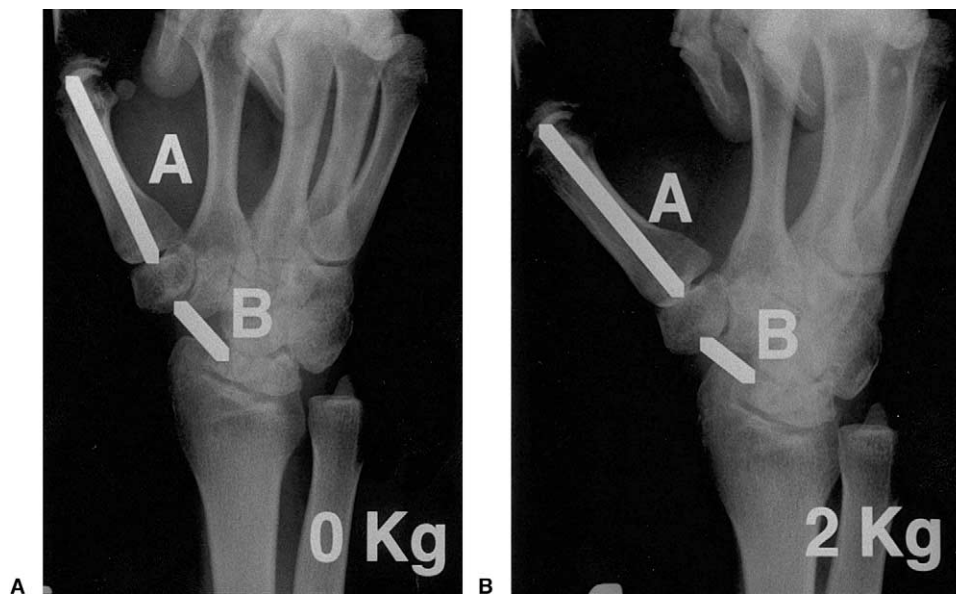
As an index of first metacarpal subsidence, the ratio of the height of the resection space divided by the length of the first metacarpal (B/A) was applied on the postoperative radiograph at rest, at 0 kg, and 2 kg key pinch.
